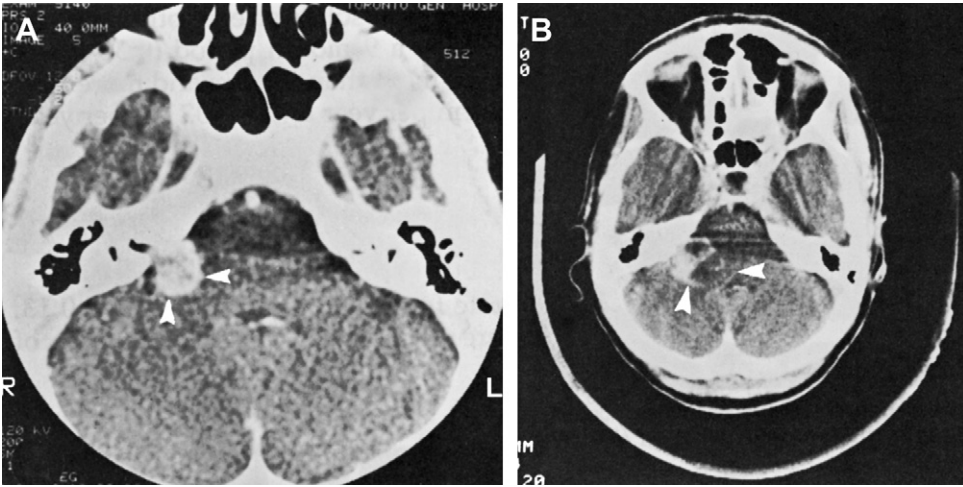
Enhanced axial computed tomography images. Tumor demonstrating rapid growth rate of 0.98 cm/yr, (1.15 cm increase in 14 months). (A) 1.45 cm in November, 1985; (B) 2.6 cm in January, 1987.
